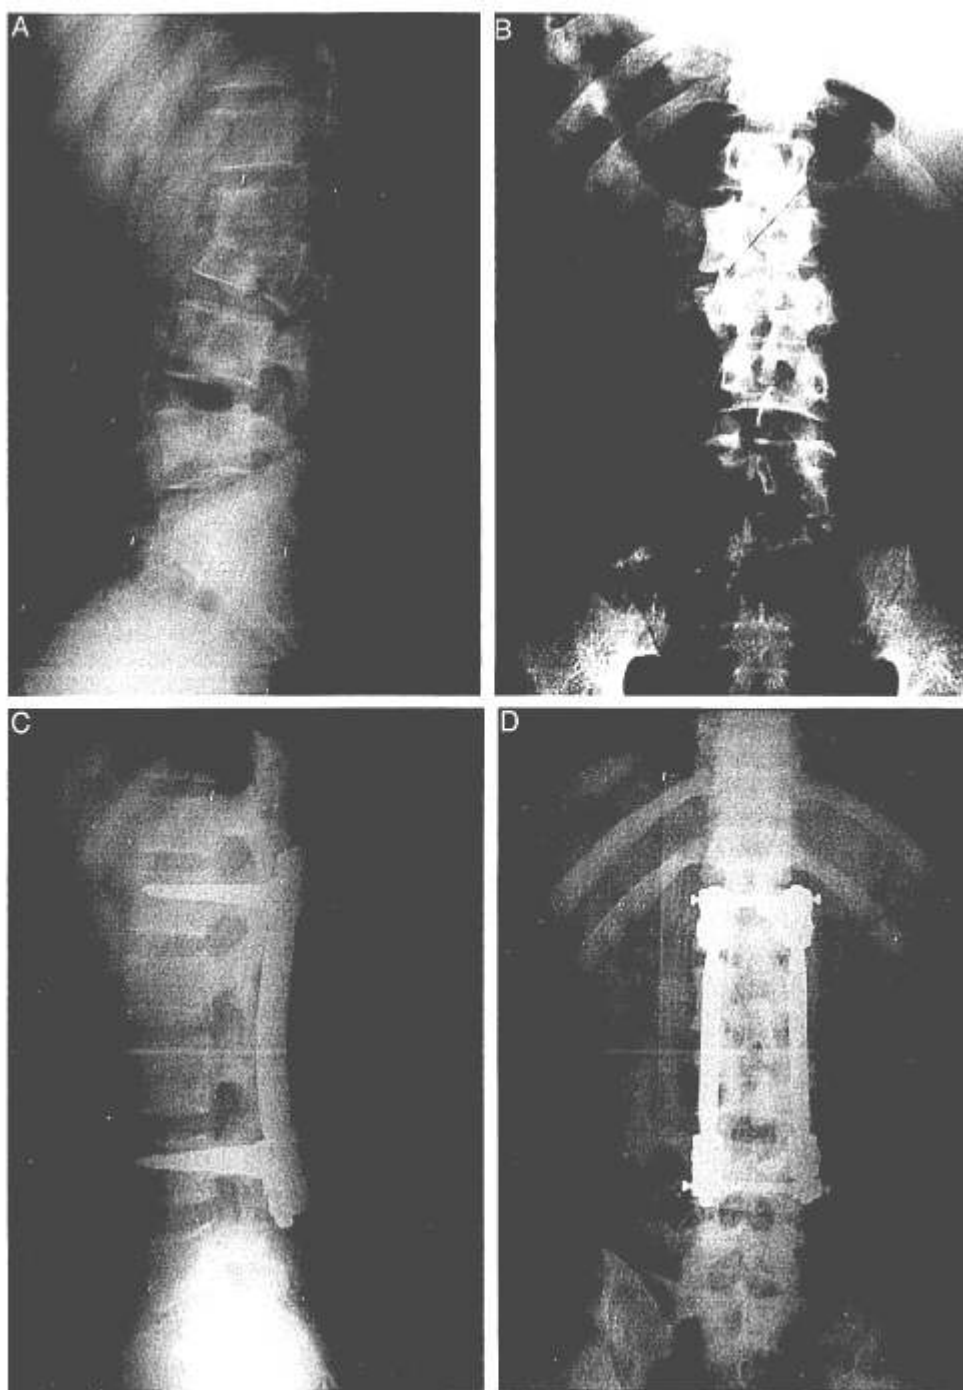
A 24-year-old man sustained both L2 and L3 burst fractures with Frankel C neurologic deficit. A,B, Preoperative anteroposterior and lateral radiographs showed a three-column disruption and kyphotic deformity. C,D, The corresponding postoperative anteroposterior and lateral radiographs showed near-anatomic reduction after reduction-fixation instrumentation.
